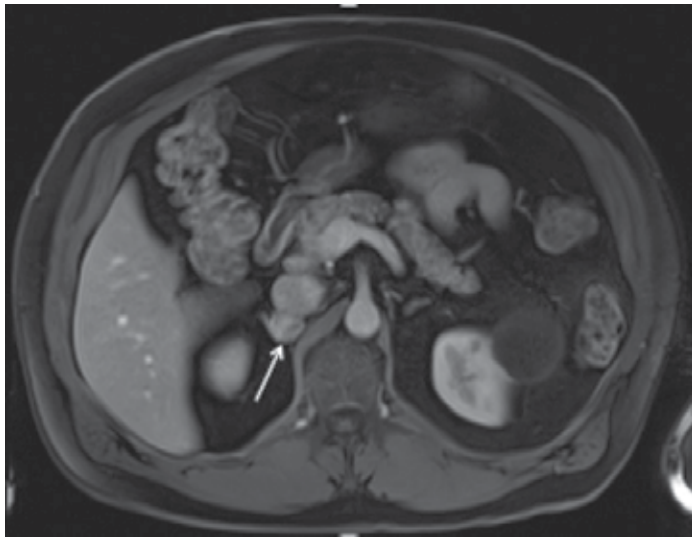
A 62-year-old male with biochemically confirmed pheochromocytoma. MRI abdomen demonstrating 1.7 cm right adrenal mass (arrow) with markedly enhanced heterogeneous T2 signal typical of pheochromocytoma.
